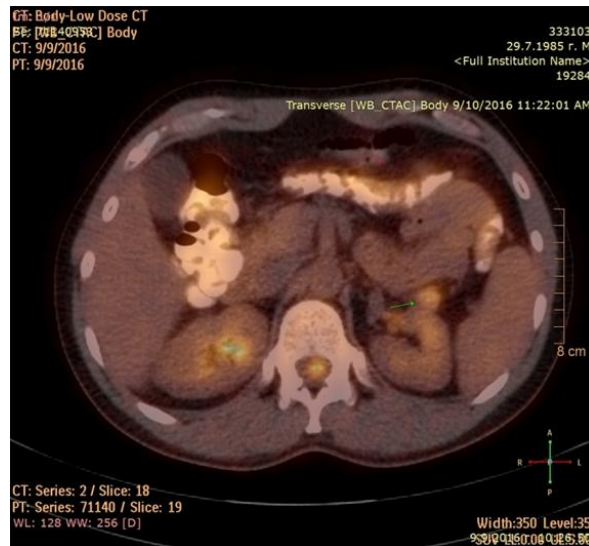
PET/CT of abdominal organs
